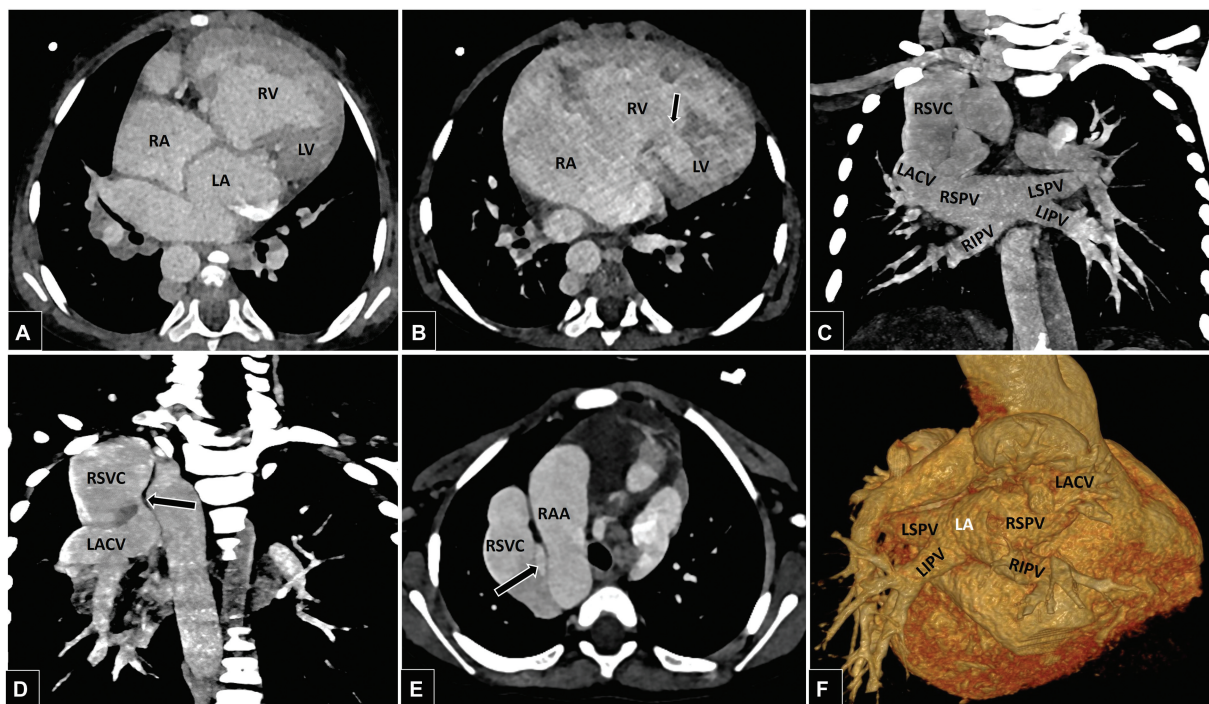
(A) Axial computed tomography (CT) image showing atretic left ventricle with mitral atresia. The interatrial septum was intact. (B) The right atrium and ventricle were dilated and there was a ventricular septal defect (arrow). (C) Coronal CT image showing the drainage of all four pulmonary veins into the left atrium. The right superior pulmonary vein was also draining into the levoatriocardinal vein (LACV). (D, E) The LACV coursed between the right SVC and right-sided aortic arch, and showed stenosis at its opening (arrows). (F) Virtual reconstructed three-dimensional image showing the drainage of all four pulmonary veins into the left atrium and the additional drainage of the right superior pulmonary vein into the LACV. LA, left atrium; LIPV, left inferior pulmonary vein; LSPV, left superior pulmonary vein; LV, left ventricle; RA, right atrium; RIPV, right inferior pulmonary vein; RSPV, right superior pulmonary vein; RSVC, right superior vena cava; RV, right ventricle.
